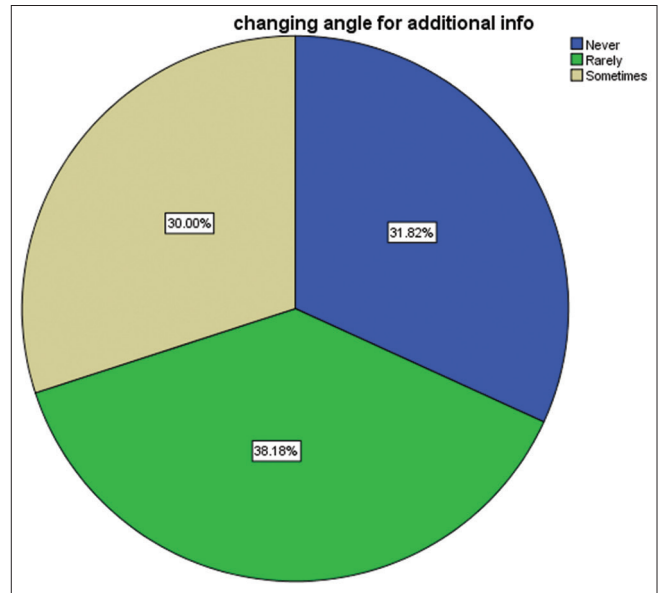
The angulation of radiographs answered by students
